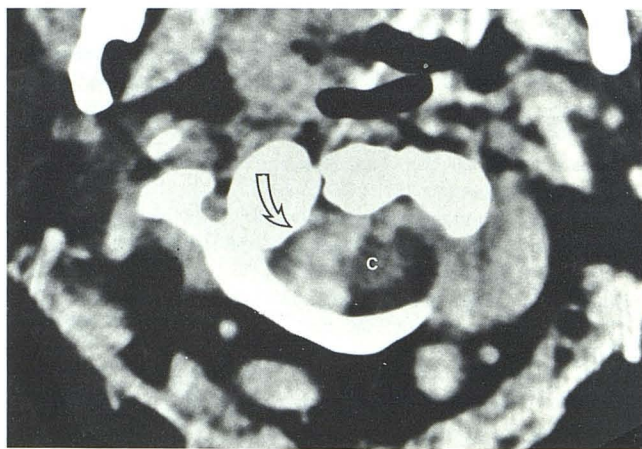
Transverse noncontrast CT scan at C1 level. Irregular high-density clot (arrow) surrounds lateral aspect of cervical cord (c), displacing it to the left.
